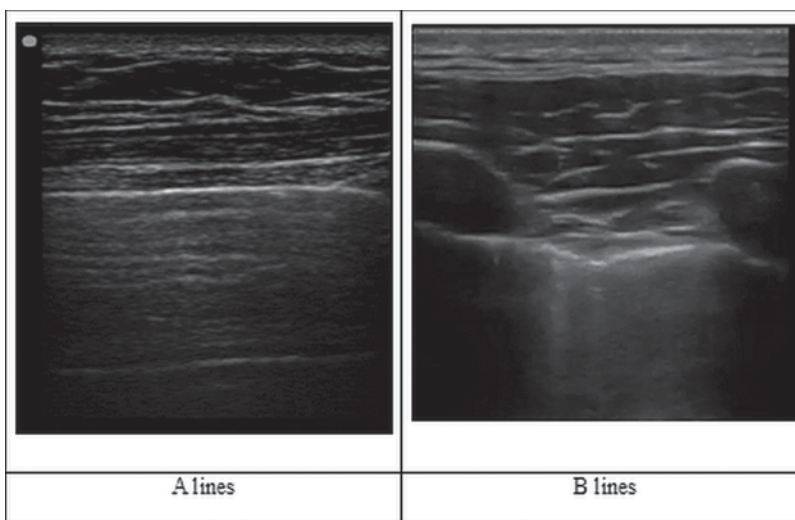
Sonographic A and B-lines
